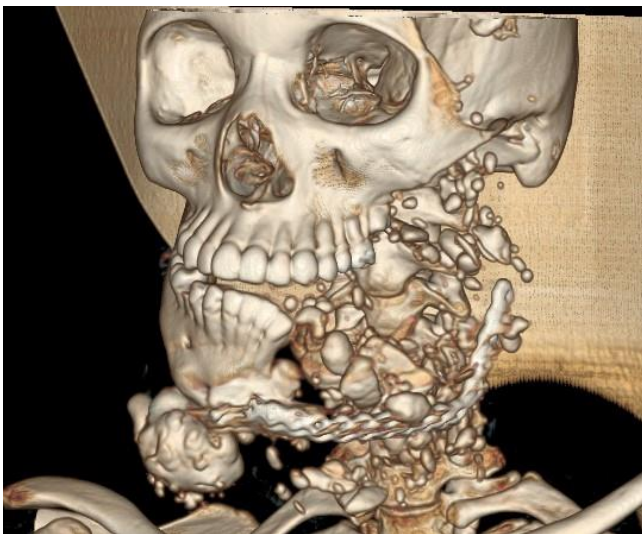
A 3-D reconstruction of a CT scan shows bony destruction at left mandible with multiple bony calcification
